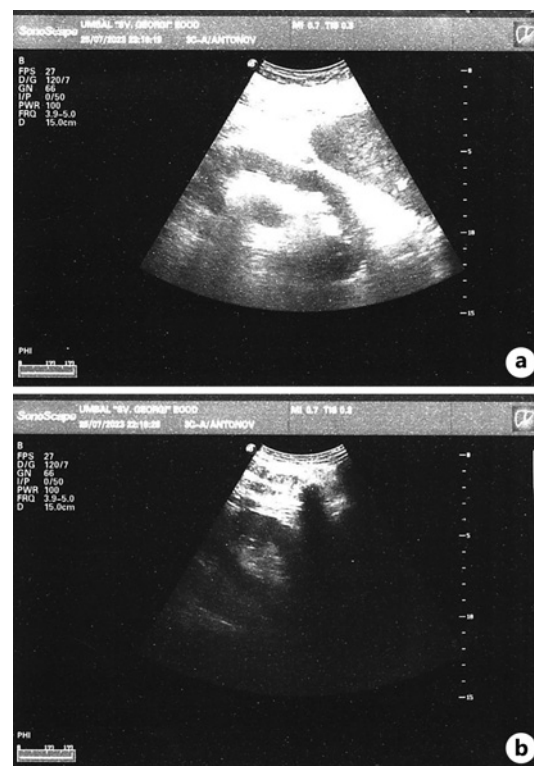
Renal ultrasound at the first ED visit. a Left kidney – anechoic area in the renal pelvis. b Right kidney is unremarkable.
